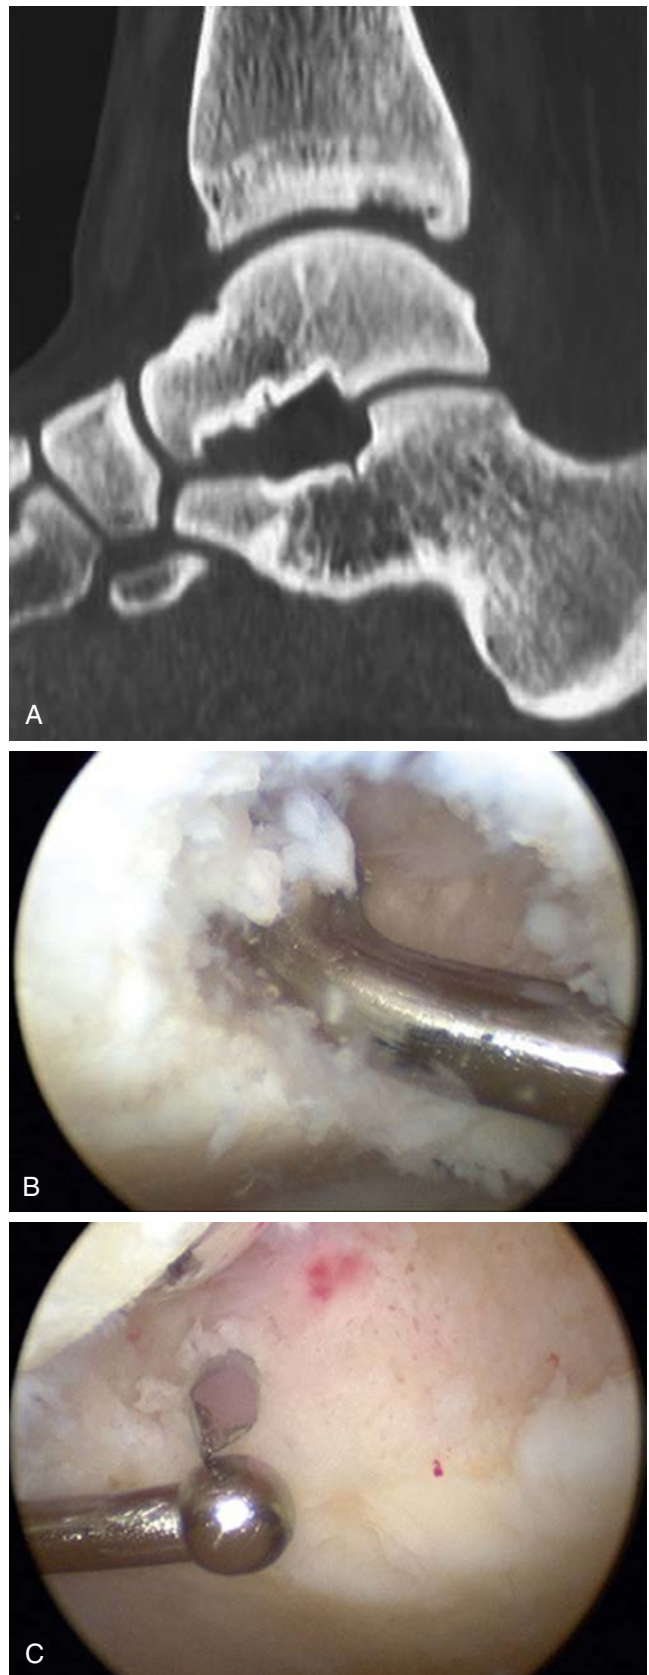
Osteochondral lesion of the tibial plafond. (A) Sagittal CT scan showing the posterior location of the osteochondral lesion of the tibial plafond. (B) Excision of the osteochondral lesion of the tibial plafond with curettes to good bleeding bone and healthy cartilage. (C) Insertion of the MicroVector™ to drill holes into the osteochondral lesion of the tibial plafond.
